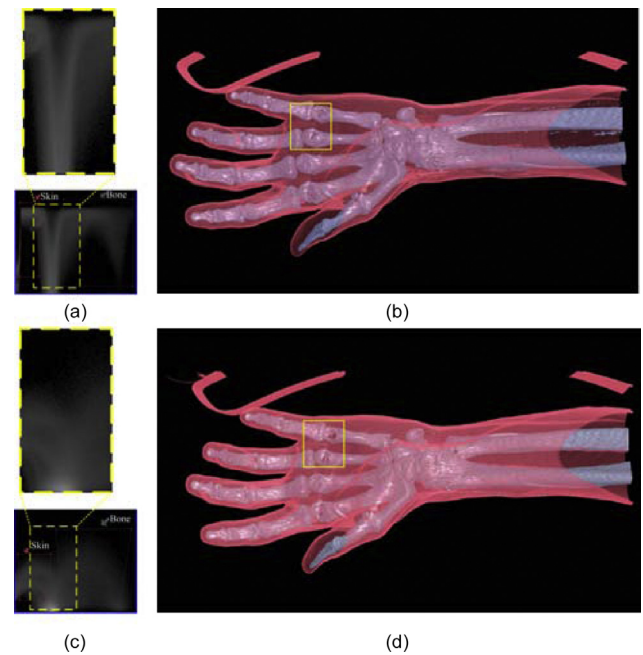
(b) Visualizations of a CT hand data by using the settings of the IS space in (a) are compared with (d) ones by using the IGM space (c). The proposed space (yellow window in (a)) can significantly reduces overlapping regions of bone and skin in the IGM space (yellow window in (c)) and obtain intuitive 'trapezoid' shapes. (For interpretation of the references to color in this figure legend, the reader is referred to the web version of the article.)
